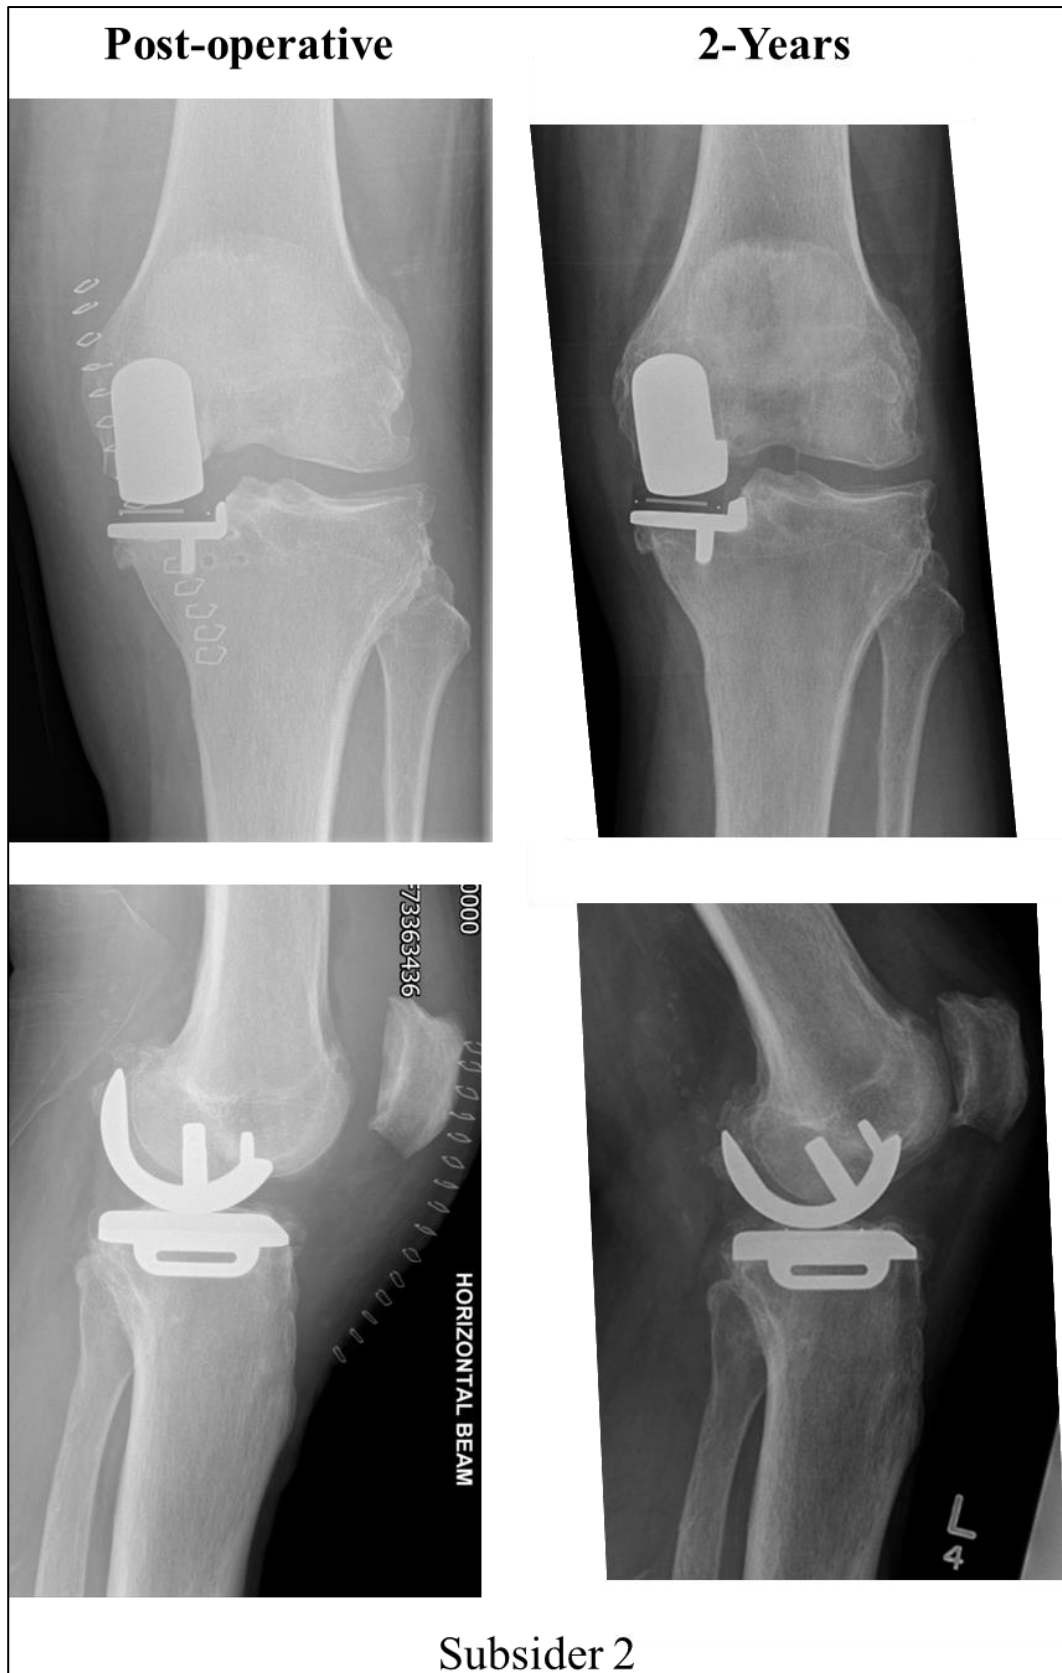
Post-operative and five-year radiographs for Subsider 2.
